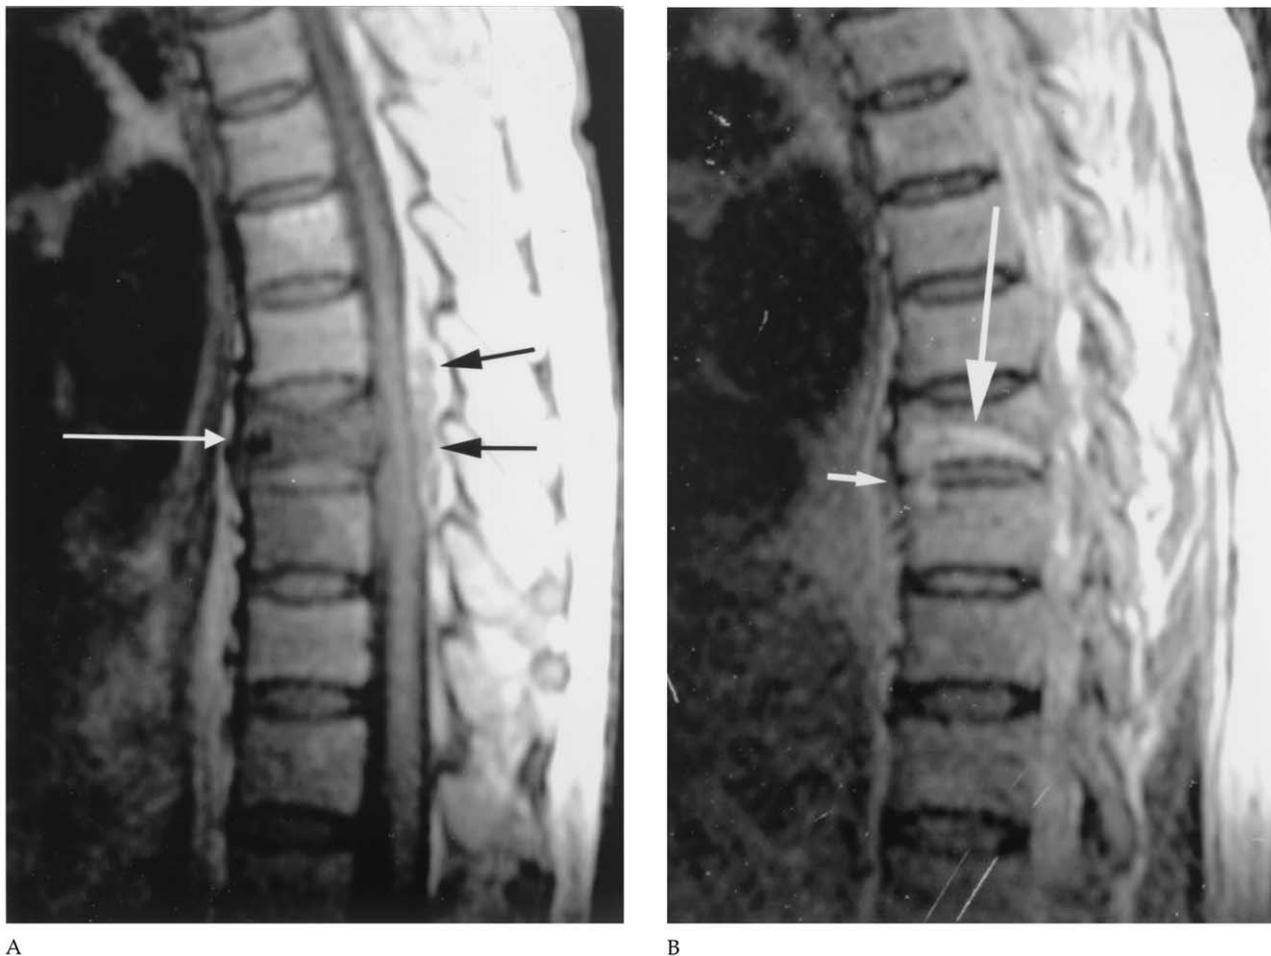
Magnetic resonance imaging of case 4. (A) Spin echo (SE) T1-weighted image on midsagittal plane. T7 vertebral body (white arrow) has hypointensity and loss of height. Posterior margin bulges into the spinal canal and causes spinal cord compression. Posterior epidural abscess (black arrows) is seen as hypointense areas within hyperintense epidural fat. Note hypointense signal in the anterior part of T8 vertebral body due to osteomyelitis. (B) Fast spin echo (FSE) T2-weighted image of the same patient on parasagittal plane. Osteomyelitis of T7 (large arrow) extends into T8 vertebral body through the anterior part of the intervening disc (small arrow).
